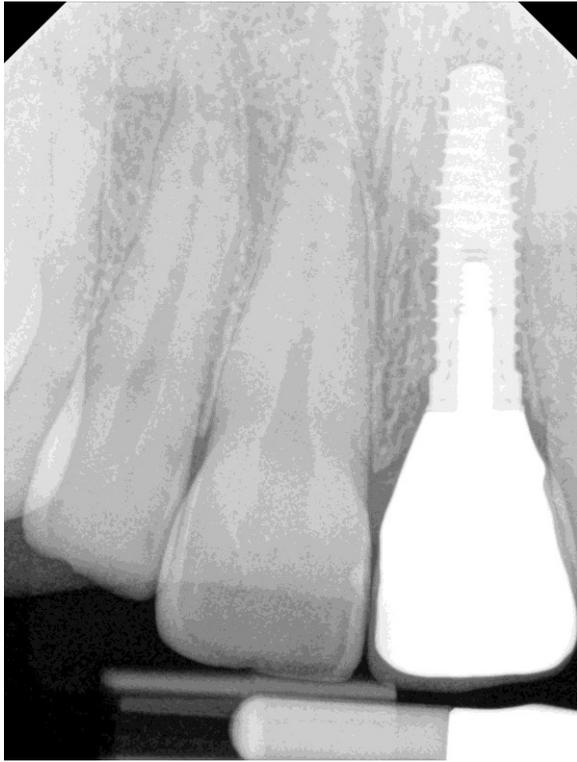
Periapical radiograph at crown delivery (postoperative month seven).
